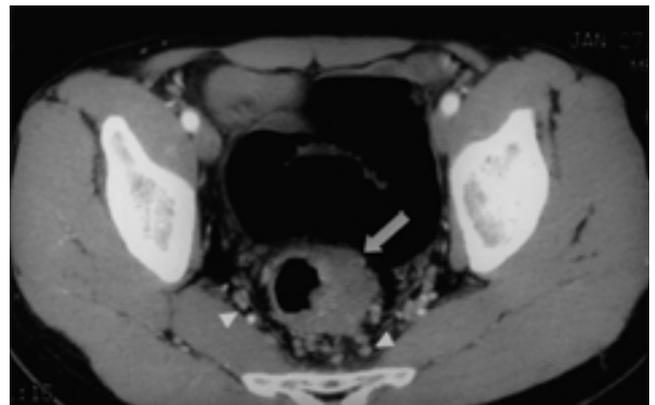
Postcontrast air insufflation helical CT shows marked wall thickening (arrow) of left lateral wall of rectum. Numerous small sized lymph nodes (arrow heads) are noted in pericolic fat (Astler-Coller classification; C2). Pathologic examination revealed multiple metastatic pericolic lymph nodes.
